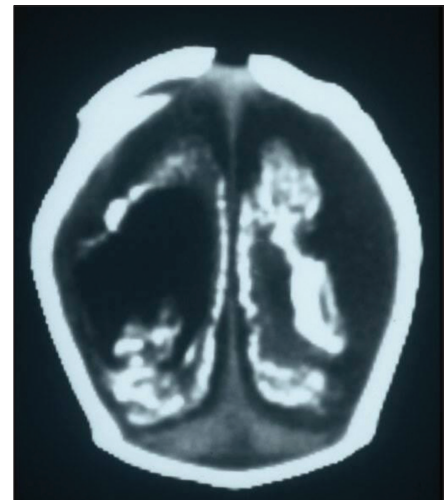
Computed tomography scan of brain from an infant born with congenital cytomegalovirus infection with severe microcephaly, over-riding sutures, enlarged ventricular system, prominent periventricular linear calcifications, and hydranencephaly. Only a portion of posterior fossa remained at birth. Examination was also remarkable for small size for gestation and bilateral chorioretinitis. This infant was treated with intravenous ganciclovir. This infant died at age 2 years from complications associated with a seasonal viral respiratory disease.
